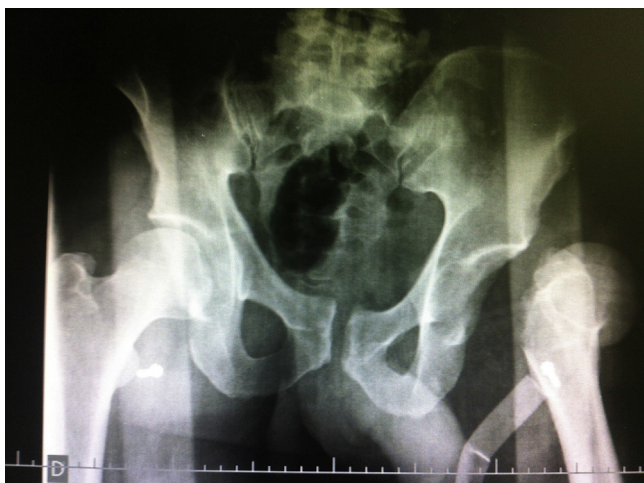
AP radiograph of the pelvis demonstrating anterosuperior dislocation of the left hip, with prominence of the lesser trochanter.
